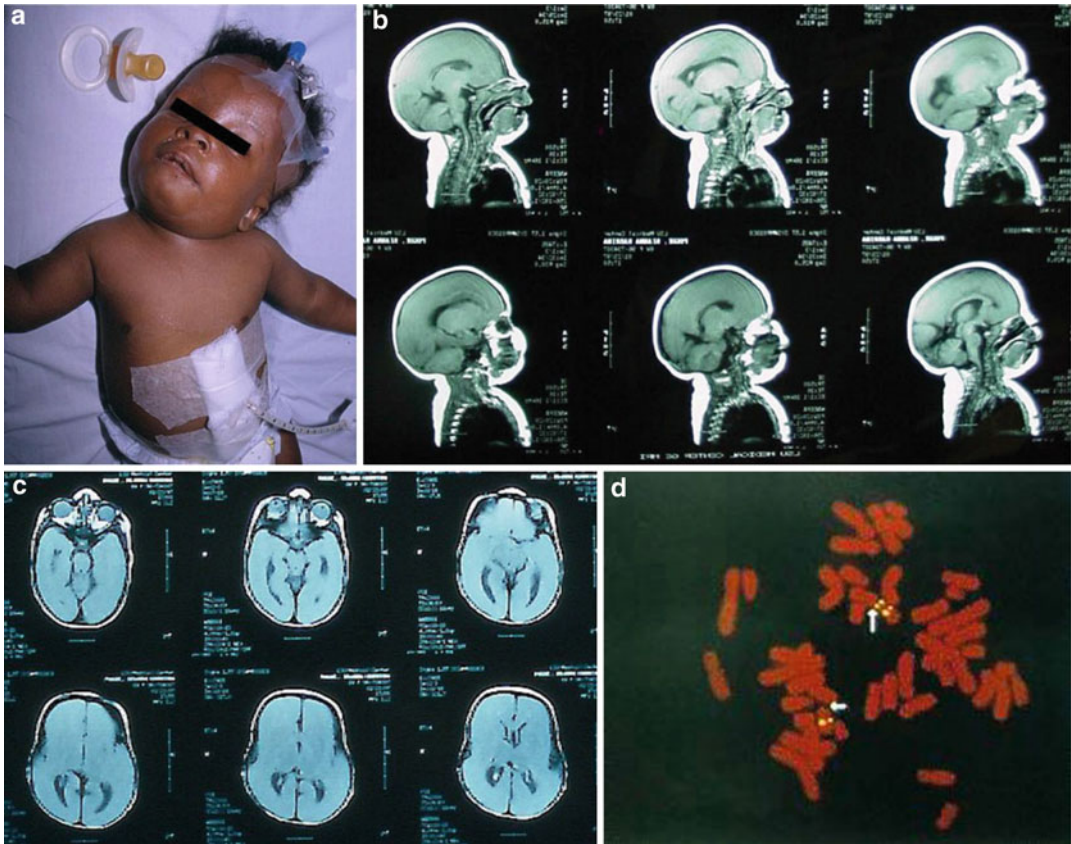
(a–d) A child with Miller-Dieker syndrome showing characteristic facial traits like the previous child. The MRI of the brain showed diffuse and complete type I
